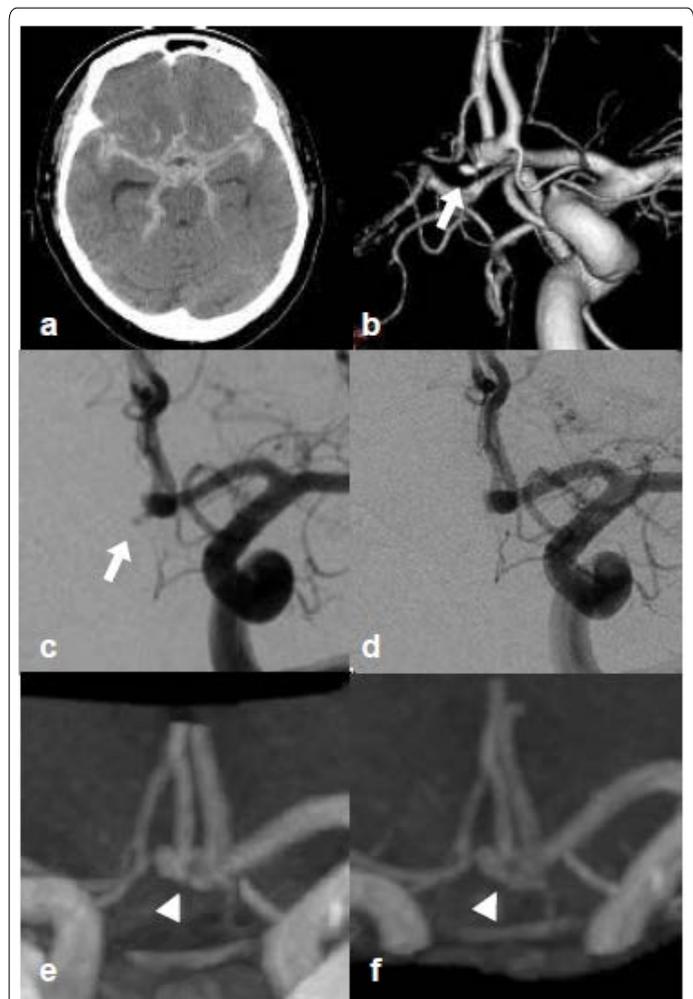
(A) A computed tomography scan of the head taken on arrival showing a diffuse subarachnoid hemorrhage. (B, C) Three-dimensional DSA (B) and a Towne's view on conventional DSA (C) of the left internal carotid artery shows a fusiform aneurysm with a bleb (arrow) on the anterior communicating artery. A Towne's view on postoperative conventional DSA shows complete obliteration of the bleb. (E, F) The bleb has not been seen on follow-up magnetic resonance angiography at 6 months (E) and 12 months (F). The fusiform aneurysm (indicated by the arrowhead) is still present. DSA, digital subtraction angiography.
